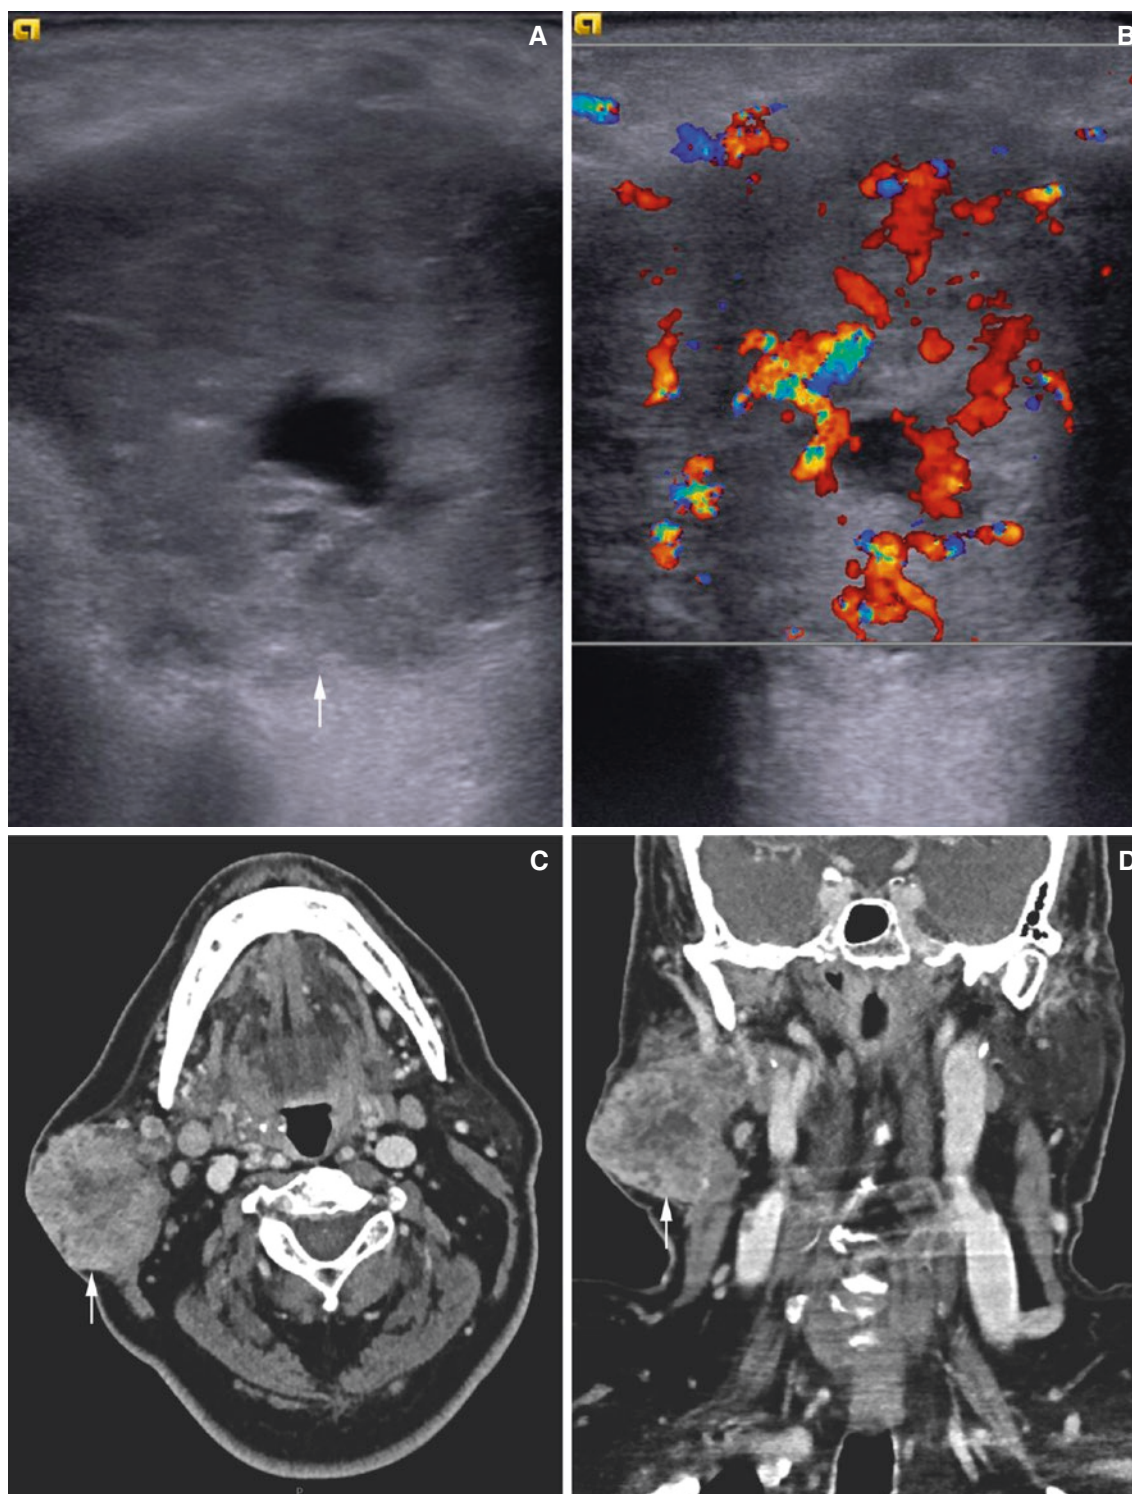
Carcinoma ex pleomorphic adenoma, parotid gland; 65-year-old male with swelling of right parotid gland area. (A) US and (B) US (Doppler) images show large intraparotid mass (arrow) with rich and patchy vascularity. Note the central area of low echogenicity indicating necrotic component raising suspicion of malignancy. (C)
